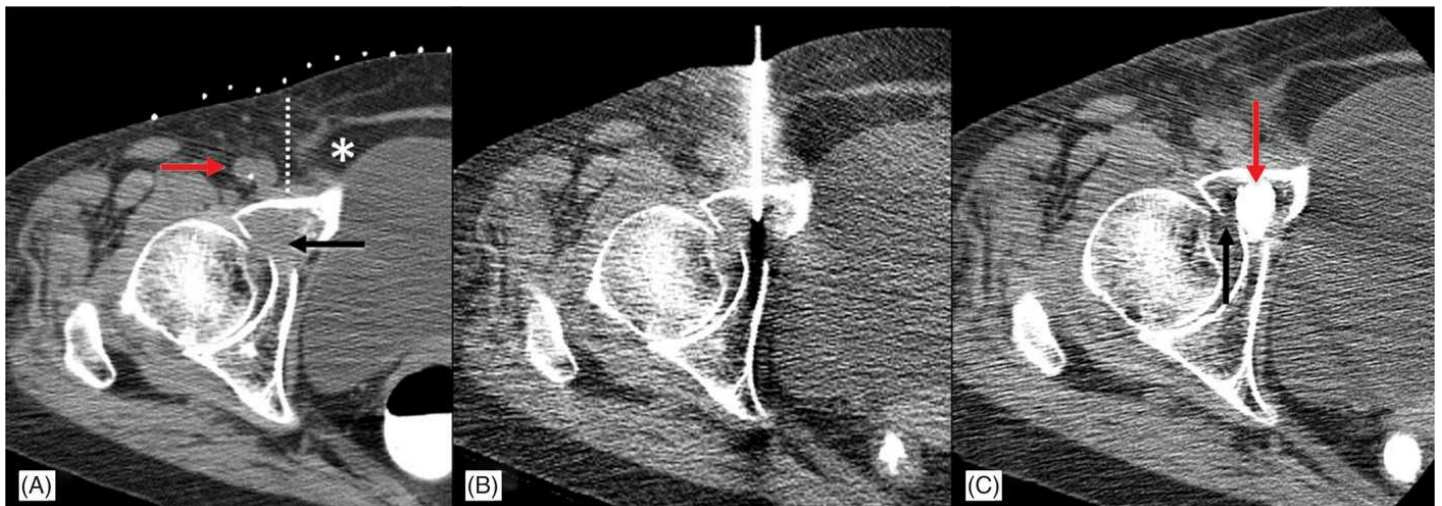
CT-guided acetabuloplasty for metastasis. (A) Axial CT clearly identifies soft tissue mass (black arrow) in anterior column of acetabulum, with narrow needle window (dotted line) between common femoral vessels (red arrow) and intra-abdominal compartment (star). (B) CT guidance allows accurate needle placement without injury to neurovascular bundle nor transgression of nontarget compartments. (C) In spite of the focal areas of cortical breach in the acetabular cortex (black arrow), careful injection of Polymethylmethacrylate (PMMA; red arrow) under CT guidance allows delivery without intra-articular extravasation.
